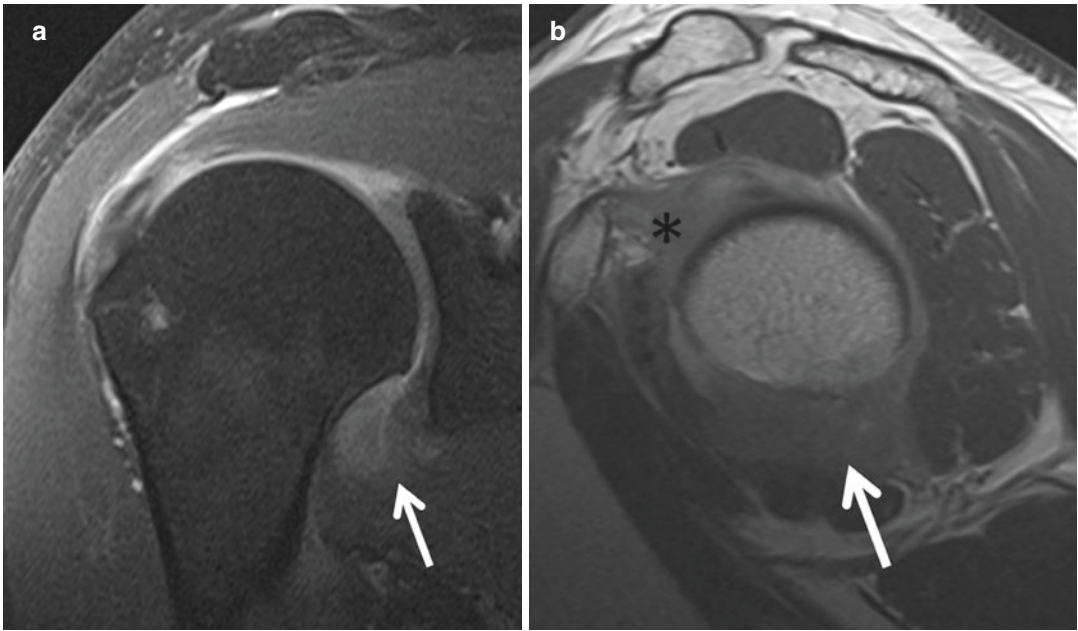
Adhesive capsulitis. (a) Coronal oblique T1-weighted fat-suppressed and (b) sagittal oblique T1-weighted images from an indirect MR arthrogram demonstrate thickening and enhancement of the axillary
